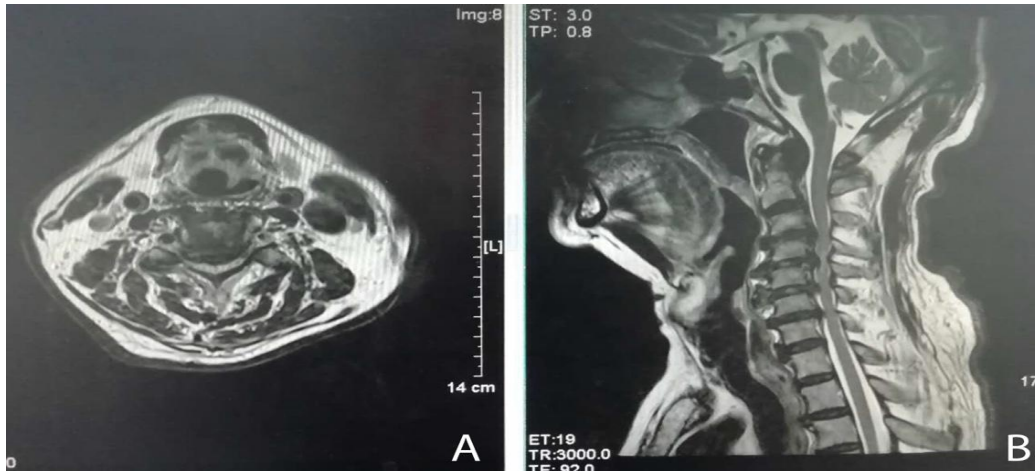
Preoperative cervical MRI. (A) Cross-section: The posterior margin of the C2 and 3 cones is slightly posterior, and the posterior longitudinal ligament is thickened and calcified. (B) sagittal plane: the cervical curvature and cone arrangement are poor, the posterior edge of the cone changes stepwise, and the 4/5 segment of the cervical vertebra is decompressed.
